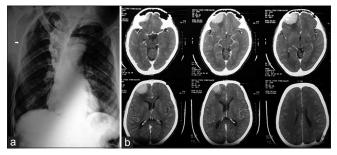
(a) Chest radiograph showing bifid ribs. (b) Computerized tomography showing meningioma
